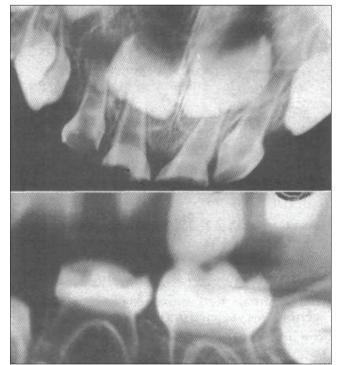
Radiographs of shell teeth of a patient with DI-III
